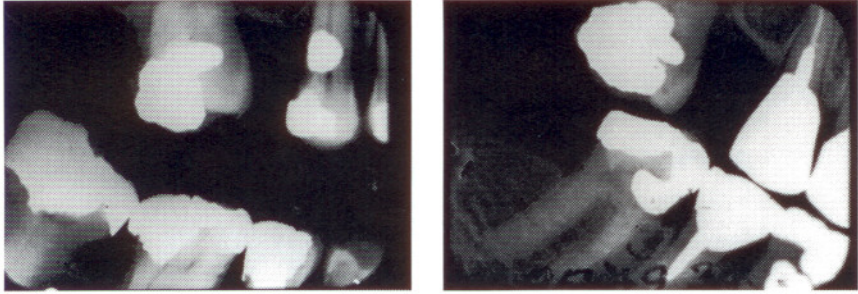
Ante-mortem (a) and post-mortem (b) radiographs of a case judged to be moderate, even though several dental characteristics have changed due to additional therapy as well as extraction of 47.
